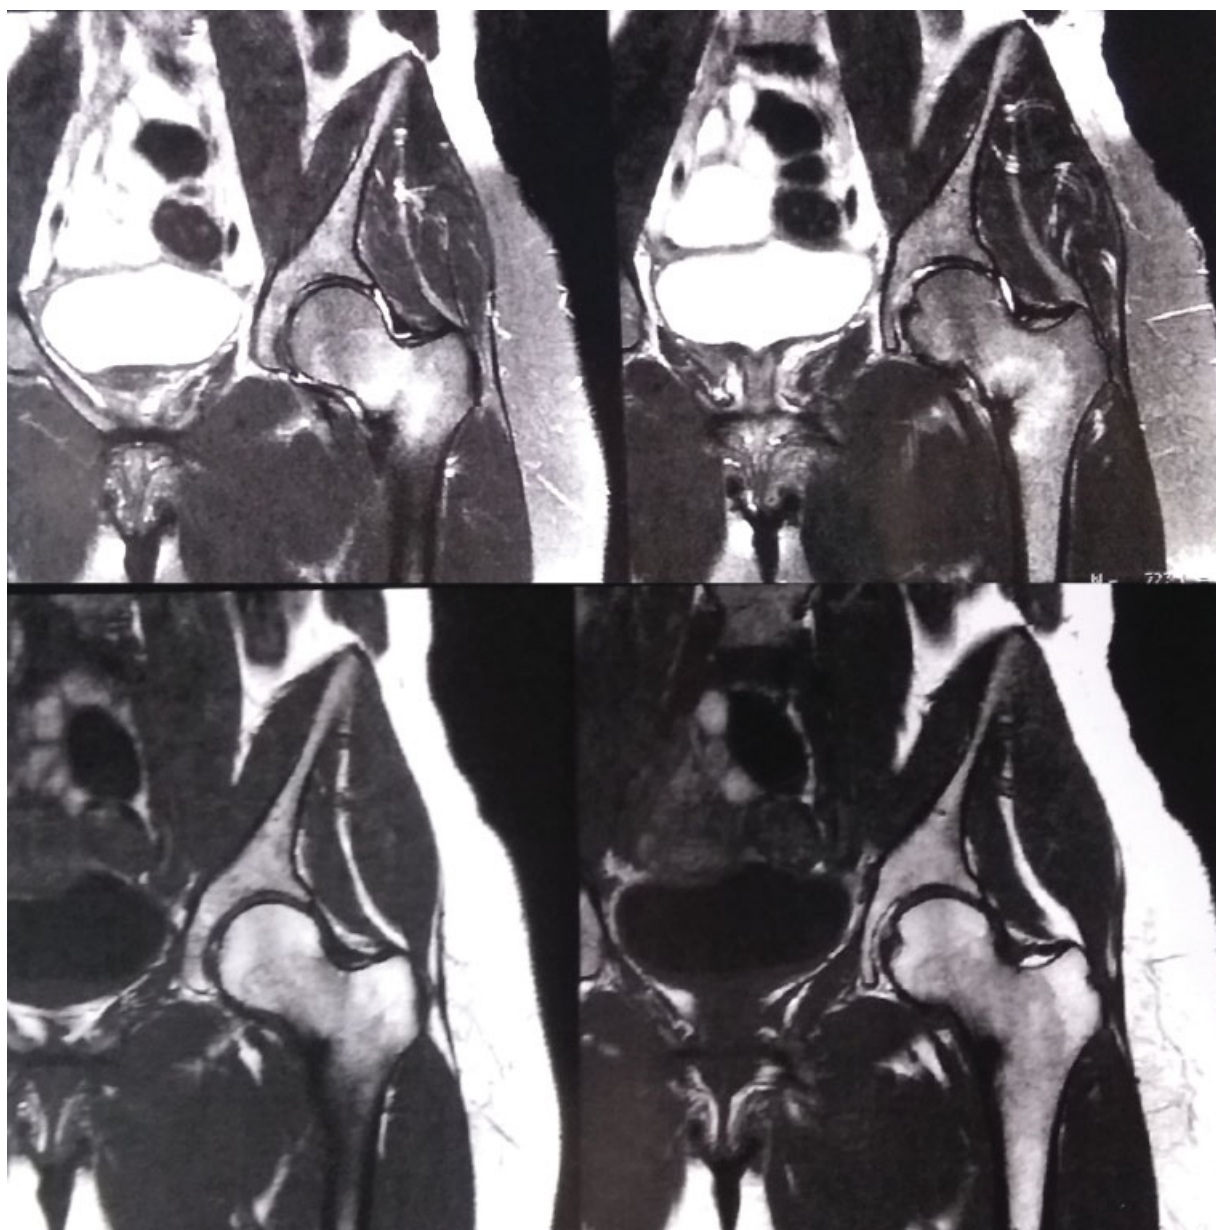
T2-weighted magnetic resonance imaging scan revealing a hypersignal at the medial cortex of the femoral neck.
